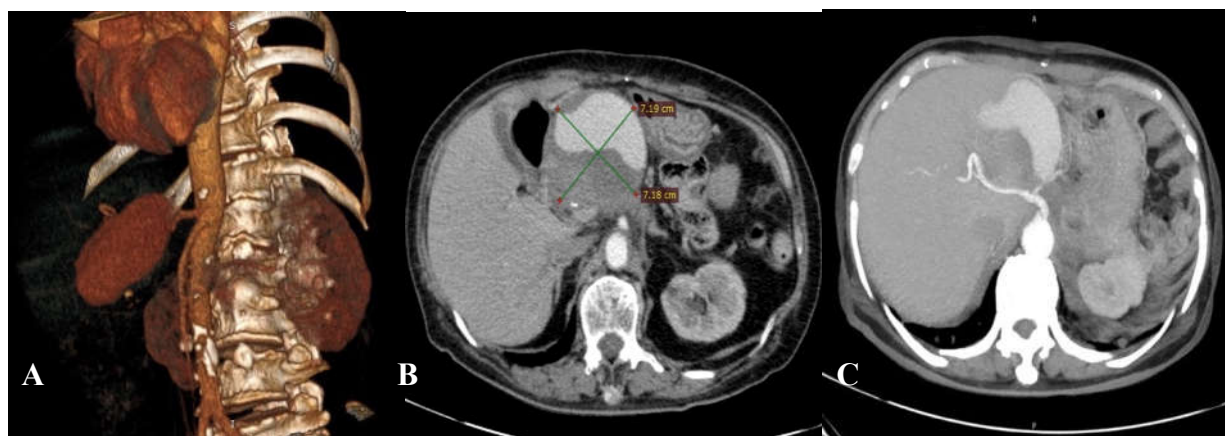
CT contrast enhancement pre-procedure. A: MIP findings demonstrate a massive pseudoaneurysm, enhance contrast in the arterial phase, narrow-neck, and originate from the GDA.
